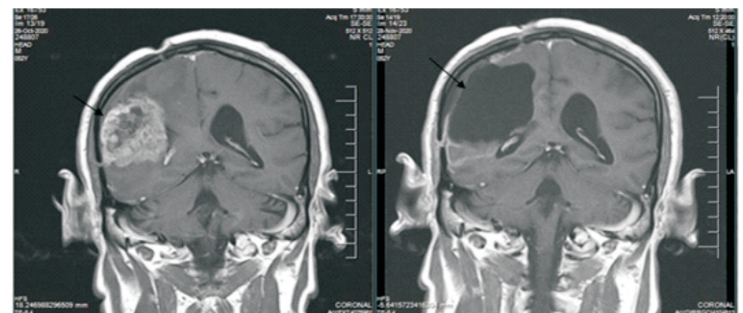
Pre-op MRI of right parietal glioblastoma
